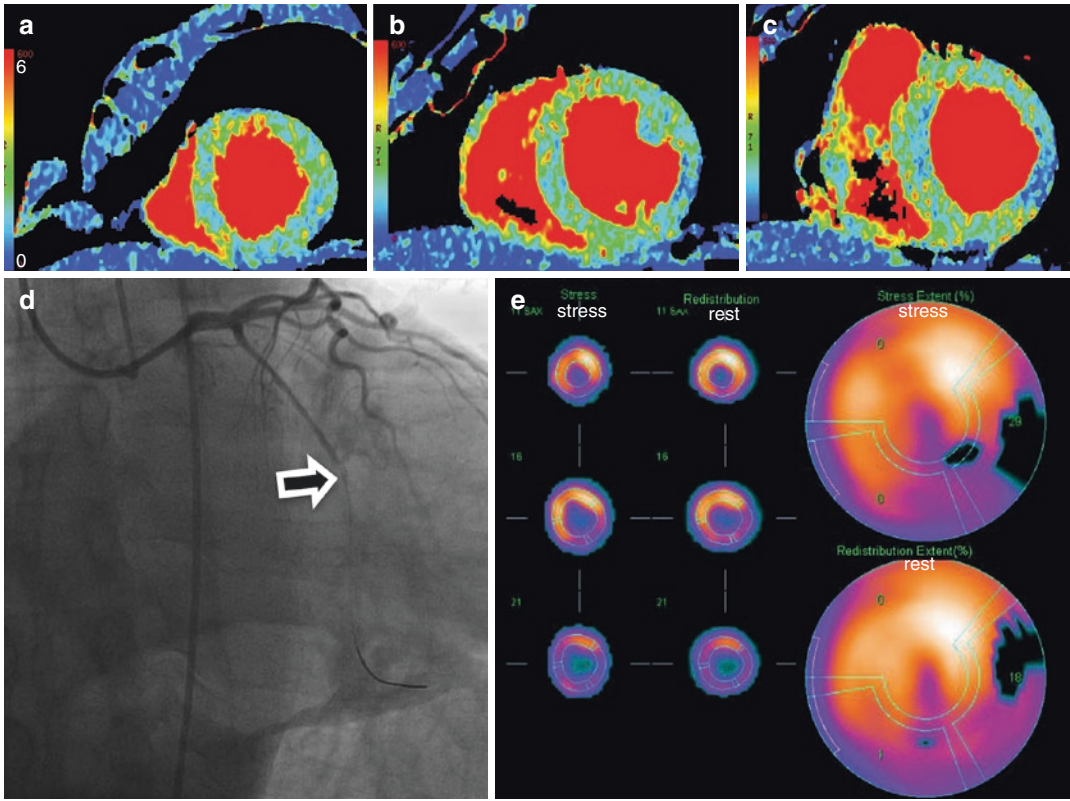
(a–c) Stress CT myocardial perfusion maps in the apical, mid, and basal short-axis slices, respectively. The color scale of the CT perfusion maps ranges from 0 (blue) to 6 (red) mL/min/g. (d) Invasive coronary angiography revealed a totally occluded obtuse marginal branch of the left circumflex artery (black arrow). (e) The SPECT
